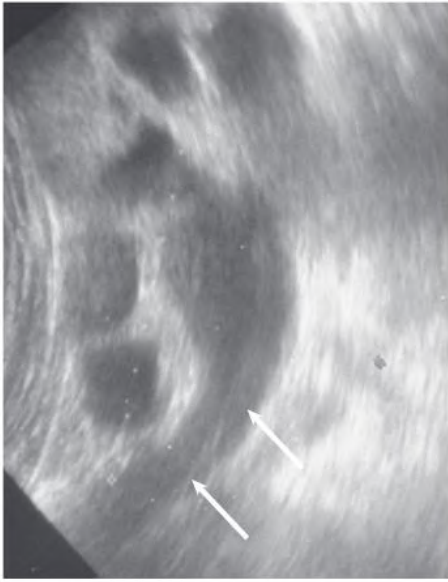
Kidney Ultrasound Scan of a Patient with Obstruction of the Urinary Tract Causing Hydronephrosis. The kidney is hydronephrotic with dilation of the pelvicalyceal system; dilation of the upper ureter is also clearly seen (arrows).
